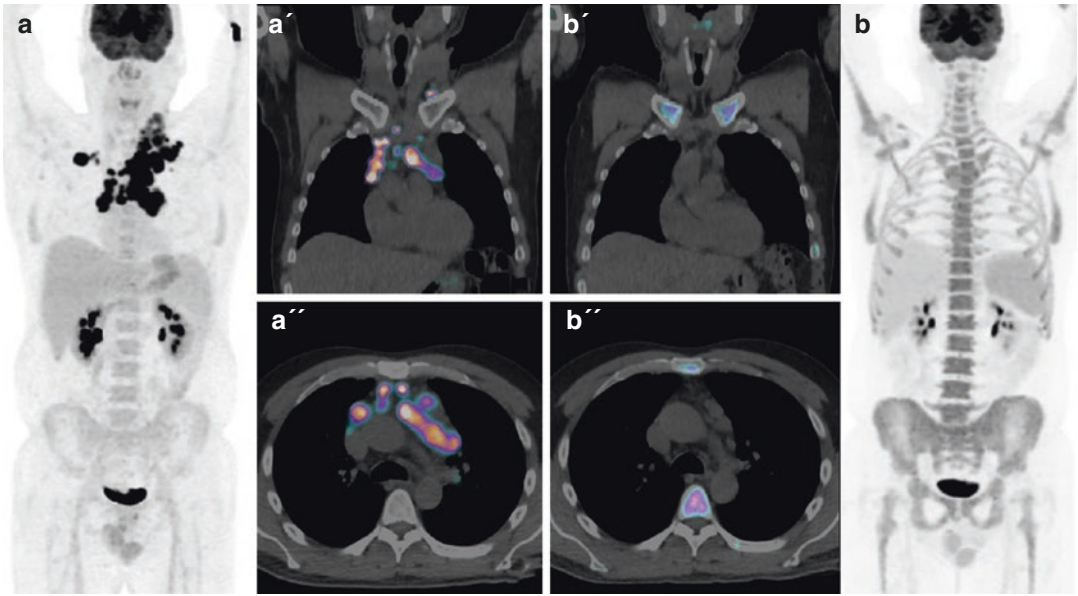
In a patient with Hodgkin lymphoma, “Baseline” ^{18}F -FDG PET/CT (a, a', a'') shows pathologic tracer uptake in cervical and mediastinal lymph nodes. After two cycles of *Adriamycin-Bleomycin-Vinblastine-*
